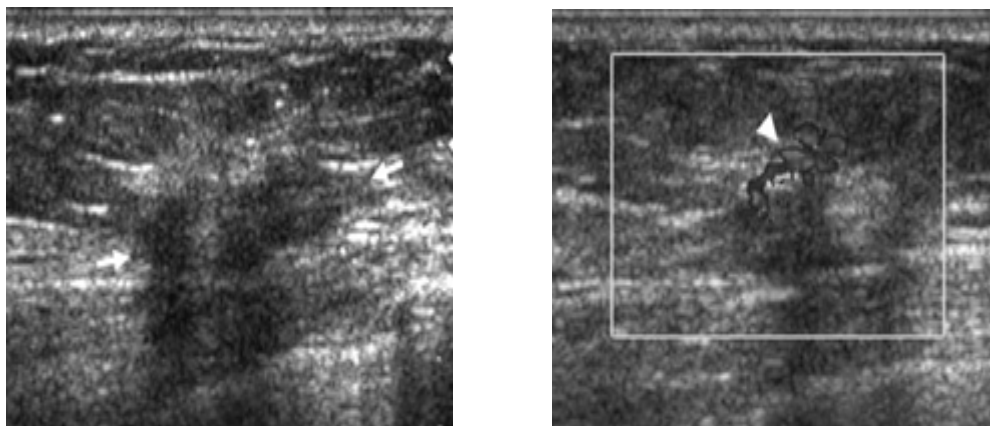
Sonograms show an irregularly shaped hypoechoic mass (arrows) with an indistinct margin and posterior shadowing.
